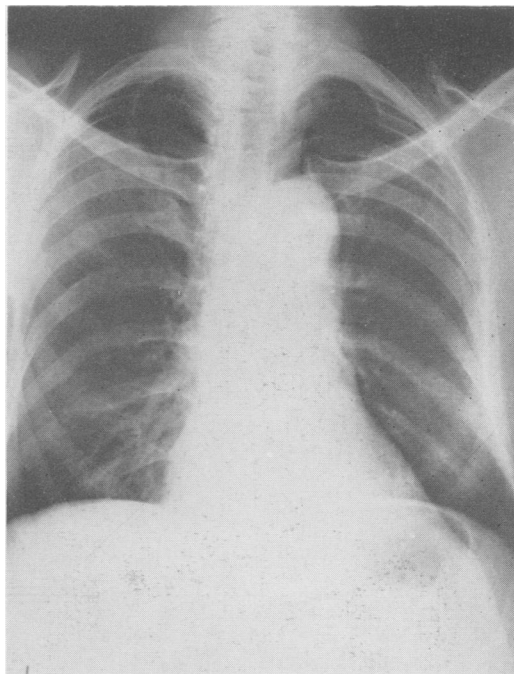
Roentgenogram of chest in Case 4, made at the time of onset of symptoms, showing moderate prominence of the aortic shadow.
